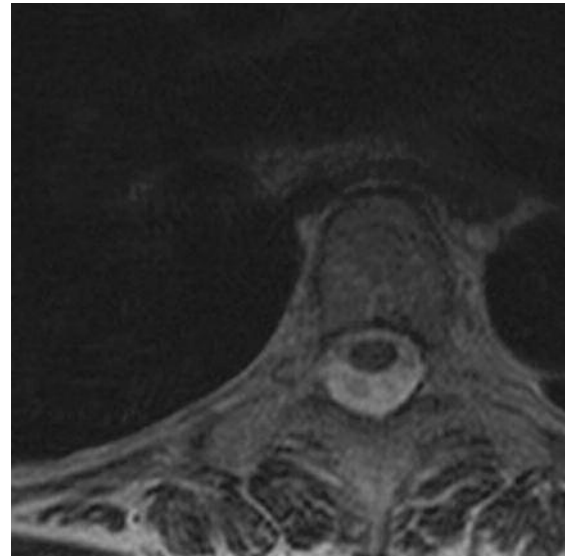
An axial T2 MRI taken six months post-treatment
